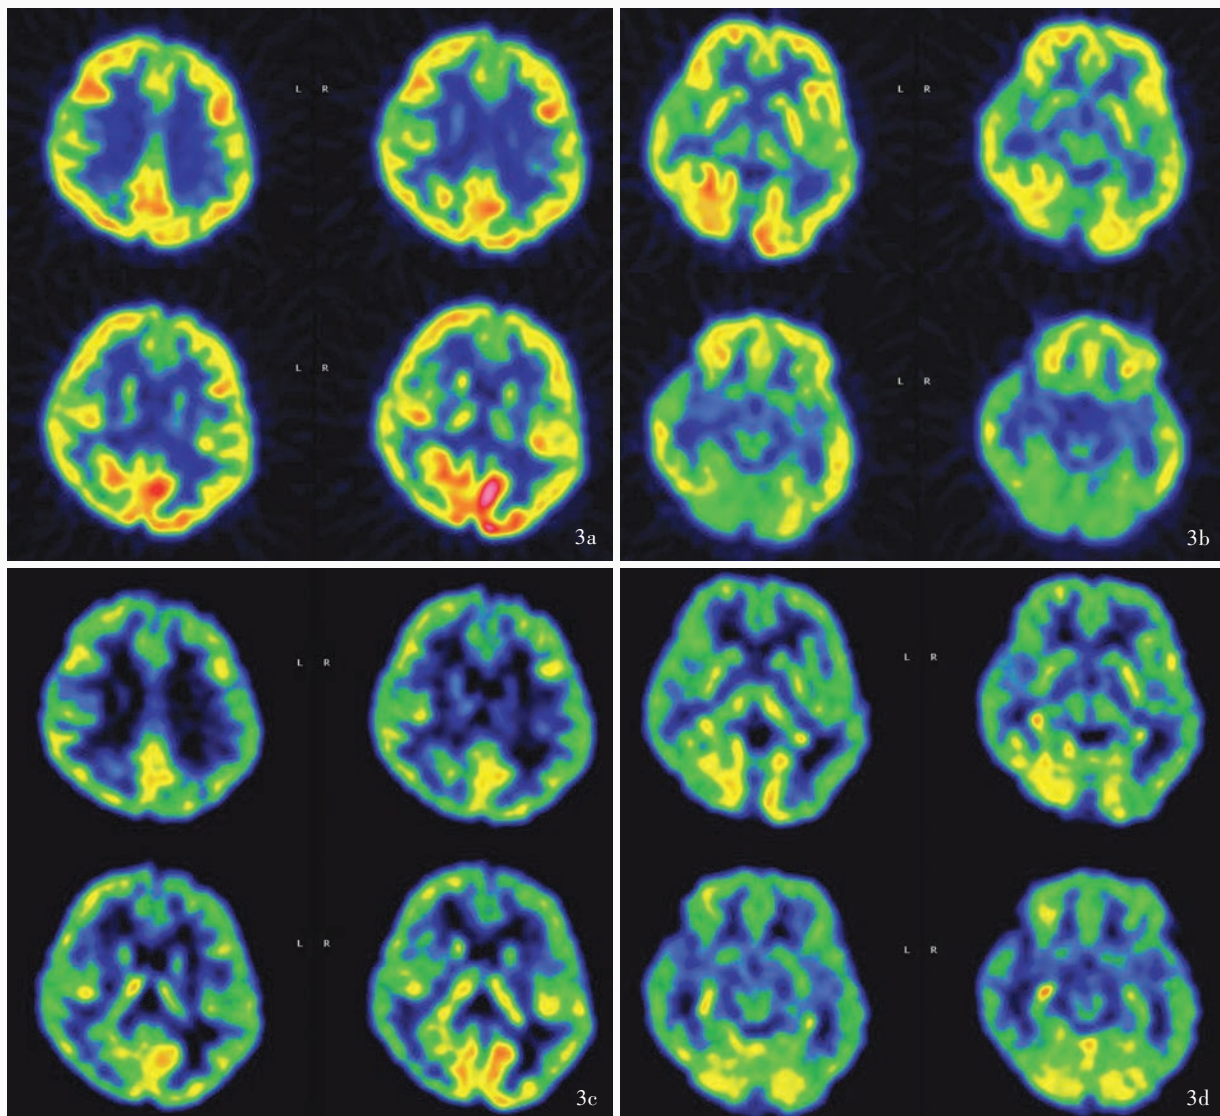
头部 PET-CT 检查所见 3a 右侧枕叶局部  $^{18}\text{F}$ -FDG 代谢浓集程度明显升高(红色区域所示),与邻近皮质近似 3b 双侧额颞叶外侧皮质  $^{18}\text{F}$ -FDG 浓集程度弥漫性降低(蓝色区域所示),无明显偏侧;双侧颞叶内侧皮质海马区  $^{18}\text{F}$ -FDG 浓集程度未见异常 3c 右侧枕叶局部血流灌注明显升高(红色区域所示) 3d 右侧海马区血流灌注较对侧升高(红色区域所示)
